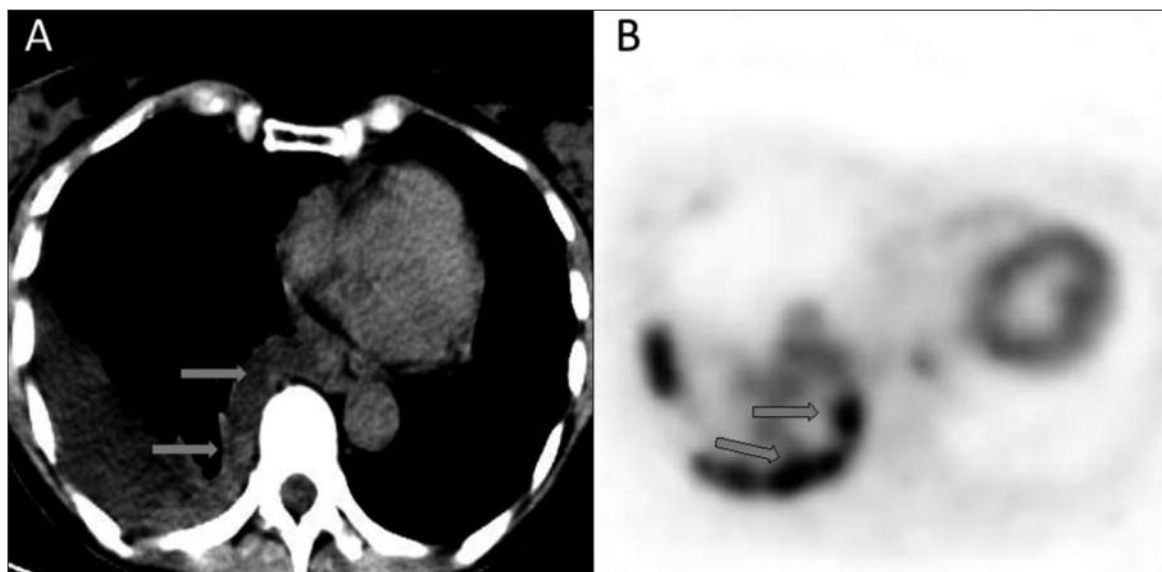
Radiological evaluation: CT-scan (A) showed an abundant right pleural effusion and diffuse pleural thickening with few pleural lesions (the largest in size measuring 40 mm of diameter) just in the azygoesophageal recess; PET-scan assessment confirmed the metabolic uptake of these lesions (B).
